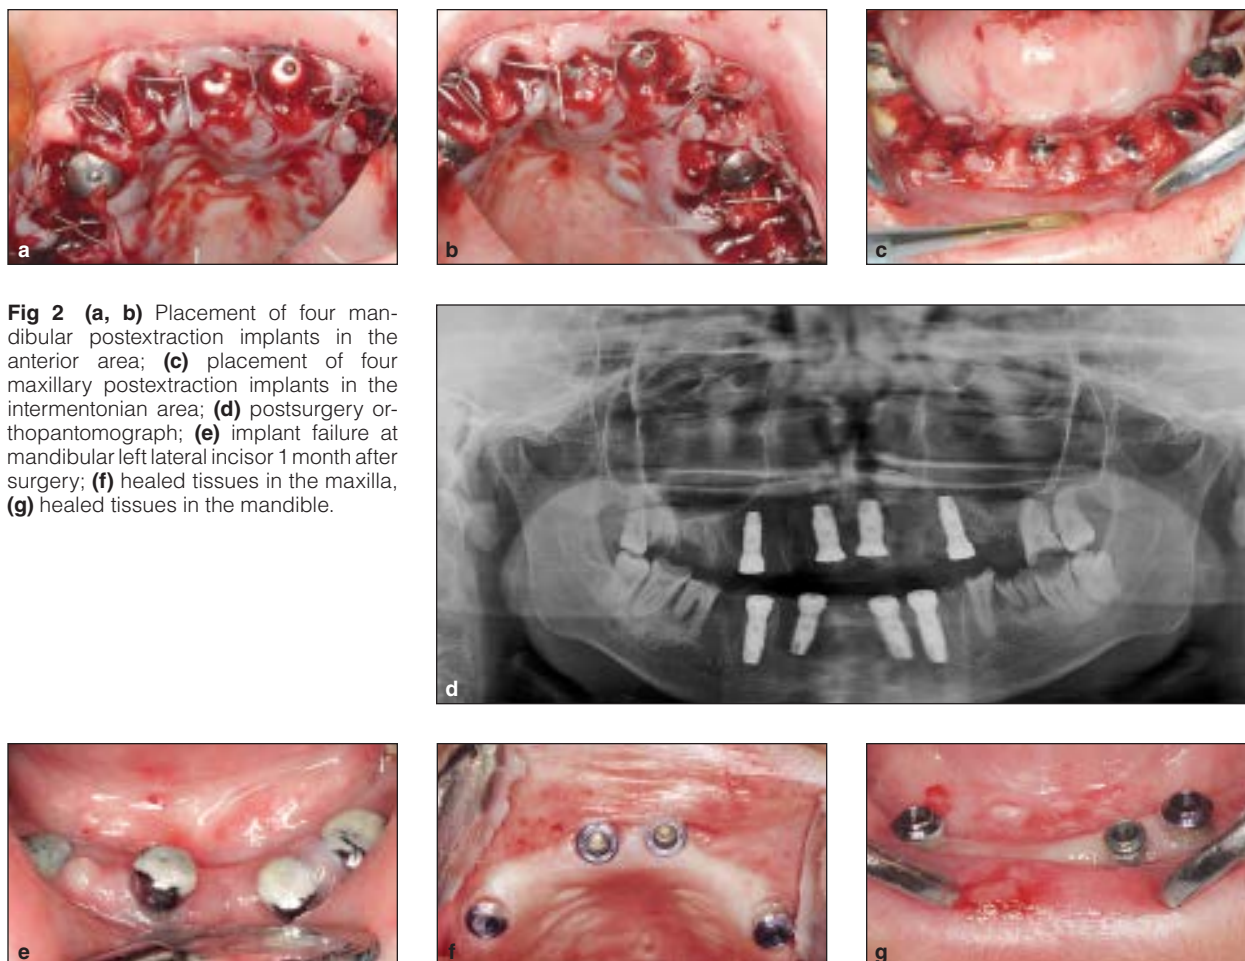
(a, b) Placement of four mandibular postextraction implants in the anterior area; (c) placement of four maxillary postextraction implants in the intermentonian area; (d) postsurgery orthopantomograph; (e) implant failure at mandibular left lateral incisor 1 month after surgery; (f) healed tissues in the maxilla, (g) healed tissues in the mandible.
